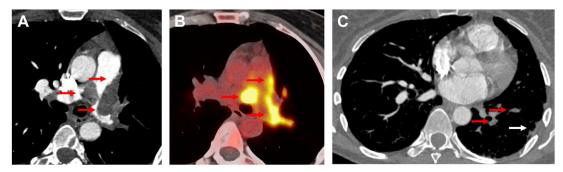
A 43 year old woman with history of Lynch syndrome, dyspnea, and chest pain. (A) Axial oblique CTPA images demonstrate central pulmonary artery masses with convex margins which were initially interpreted as acute pulmonary embolism. (B) Subsequent PET-CT demonstrated heterogeneous fluorodeoxyglucose (FDG) uptake of the mass which may be due to admixed bland thrombus or non-FDG avid tumor. (C) Left lower lobe segmental arteries are occluded and diminutive (*red arrows*) relative to right-sided pulmonary arteries with associated infarct (*white arrow*), mimicking CTEPH. This may have been due to tumor, bland thrombus, or a combination of both.
